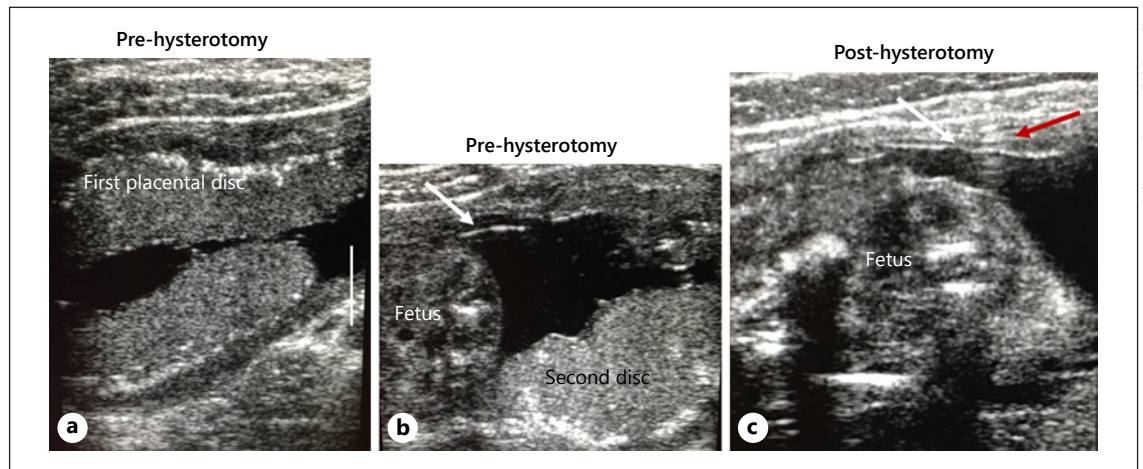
Ultrasound images before (a, b) and after hysterotomy (c). a, b Before hysterotomy the location of the placental discs was verified and intact membranes (white arrow) and viability of the fetus were confirmed. c The post-hysterotomy scan showed intact membranes (white arrow) at the site of the uterine scar (red arrow indicates artifact from a suture). The scale bar in a denotes 1 cm.
